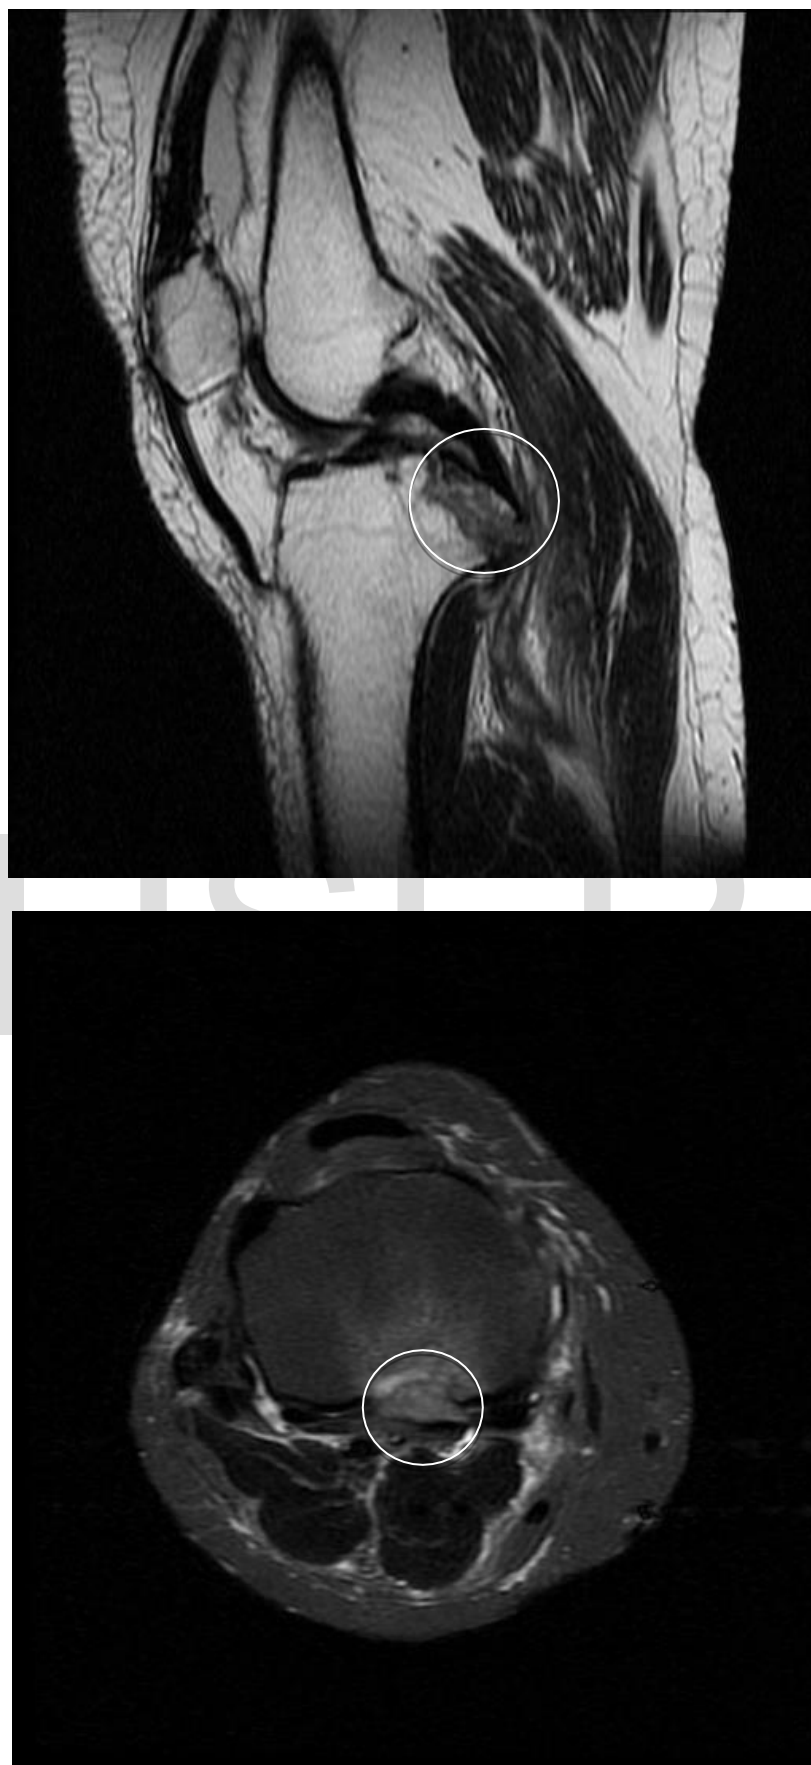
PRE-OP MRI SHOWING PCL TIBIAL AVULSION
